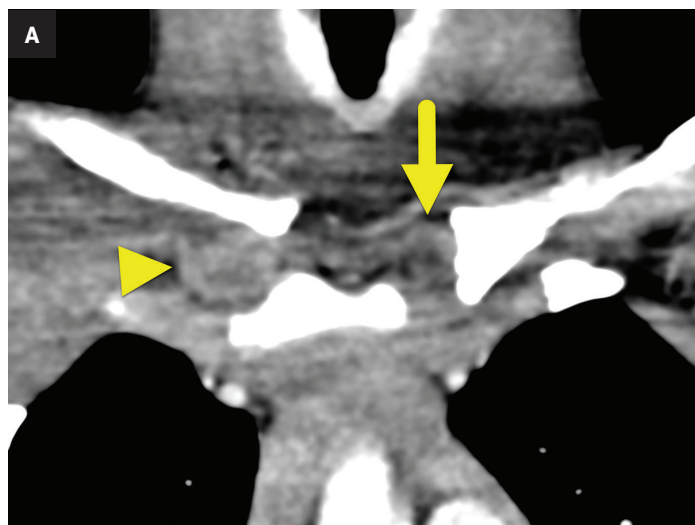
(A) Coronal CT of the chest centered on the sternoclavicular joints shows superior and medial displacement of the right clavicle. The right sternoclavicular cartilage (arrowhead) remains articulated with the manubrium. There is no cartilage associated with the medial right clavicle. The left sternoclavicular joint is intact with normal positioning of the medial clavicular cartilage (arrow). (B) Axial maximum intensity projection image shows posterior displacement (arrow) of the right clavicle in relation to the manubrium. (C) 3D reformatted image shows the elevated and medially displaced right clavicle (arrow).
